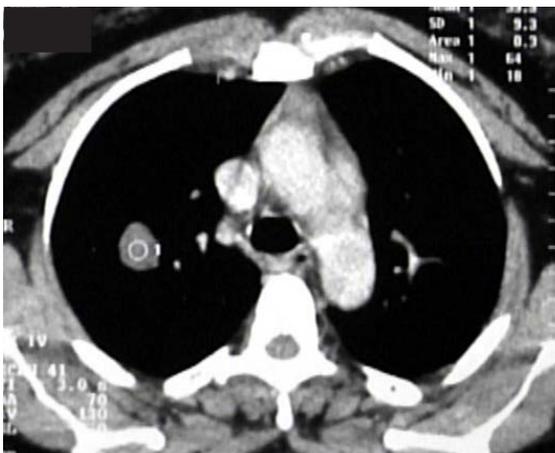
Computed tomography of the chest using a window for the mediastinum, revealing a lesion in the upper right lobe
